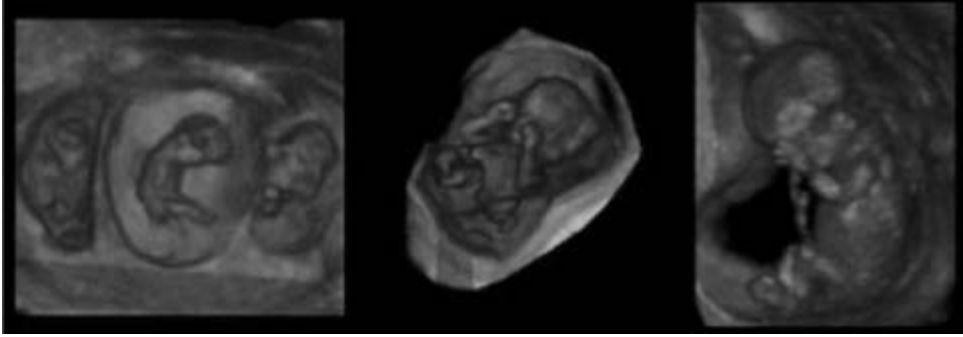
From left to right, photos are images of first trimester fetuses captured by noninvasive 3D ultrasound. Photo 1 is 11-week-old triplet fetuses, photo 2 is a 12-week-old fetus with arms brought to face, and photo 3 is a 13-week-old singleton fetus. (Photos courtesy of (1) Dr. Martin Metzenbauer, Austria; (2) Dr. Armin Breinl, Austria; (3) Dr. Leonardo Mandujano, Chile)
